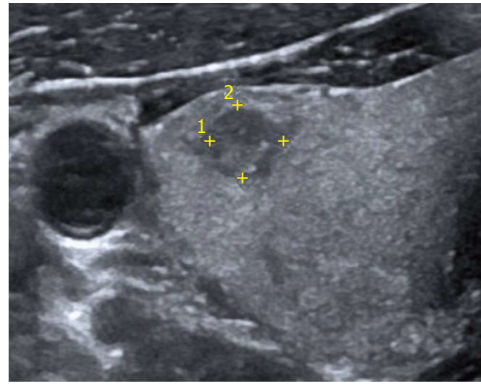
High resolution ultrasonography of the neck reveals a well-defined heteroechoic lesion in the right lobe of thyroid gland which appeared indeterminate on imaging (TIRADS 4B).
